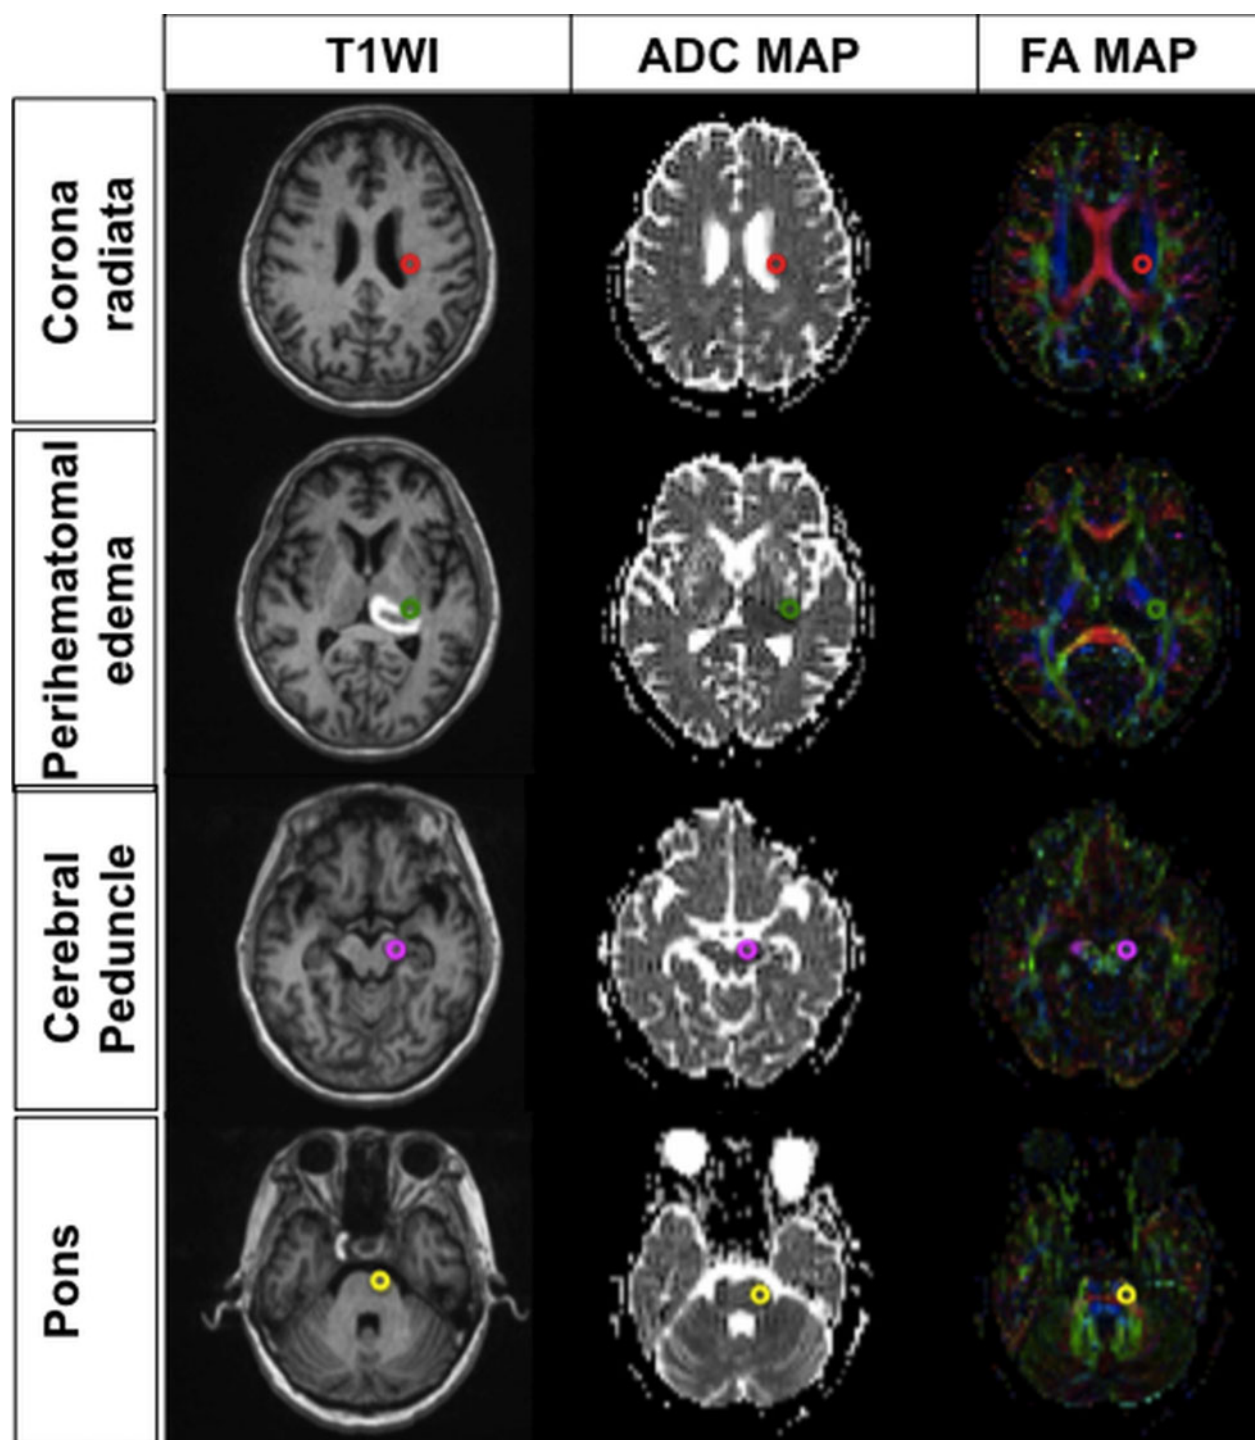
Diffuse tensor image of four regions of interest. The small circles indicate the regions of interest over the damaged corticospinal tract (CST) in axial T1-weighted imaging (T1WI), apparent diffusion coefficient (ADC) map and FA map images. The regions of interest are shown in red (corona radiata), green (perihematomal oedema), purple (cerebral peduncle) and yellow (pons).
